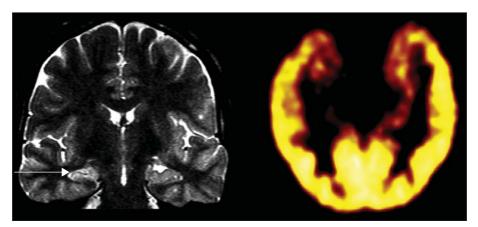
[11 C]flumazenil-PET (FMZ-PET) in a patient with right TLE and mesial temporal sclerosis on MRI, showing a typical decreased FMZ binding over the atrophic hippocampal region.
